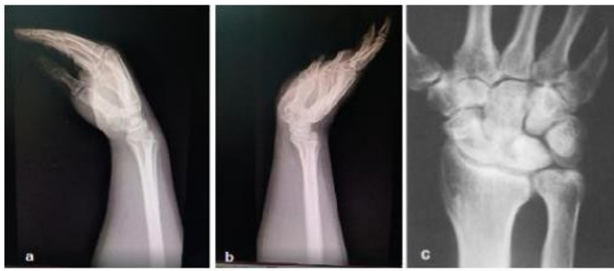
Dorsopalmar and lateral radiographs of the right wrist in flexion and extension at two years of postoperative follow-up showing minimal sclerosis, without collapse of the lunate.
